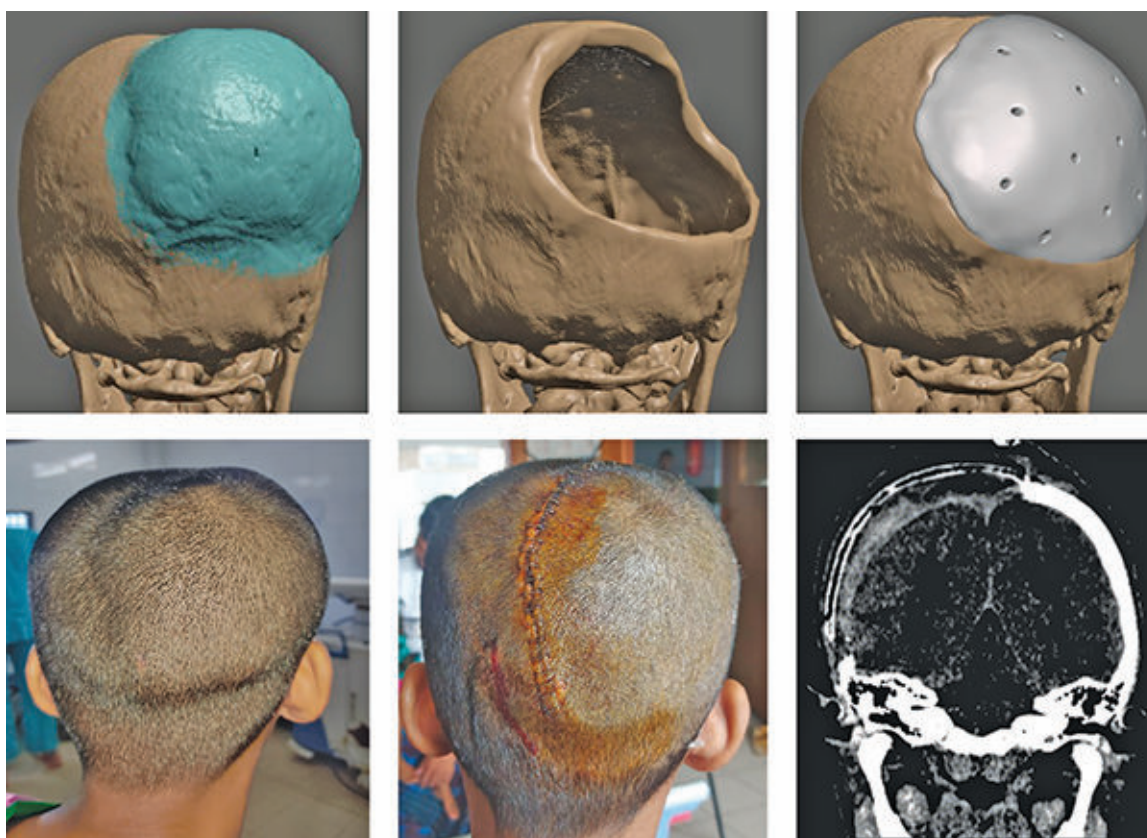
Large right Parieto-occipital FD; Upper Row: Designing implant in CAD software, Lower row: Preoperative and postoperative picture of patient and postoperative CT scan
